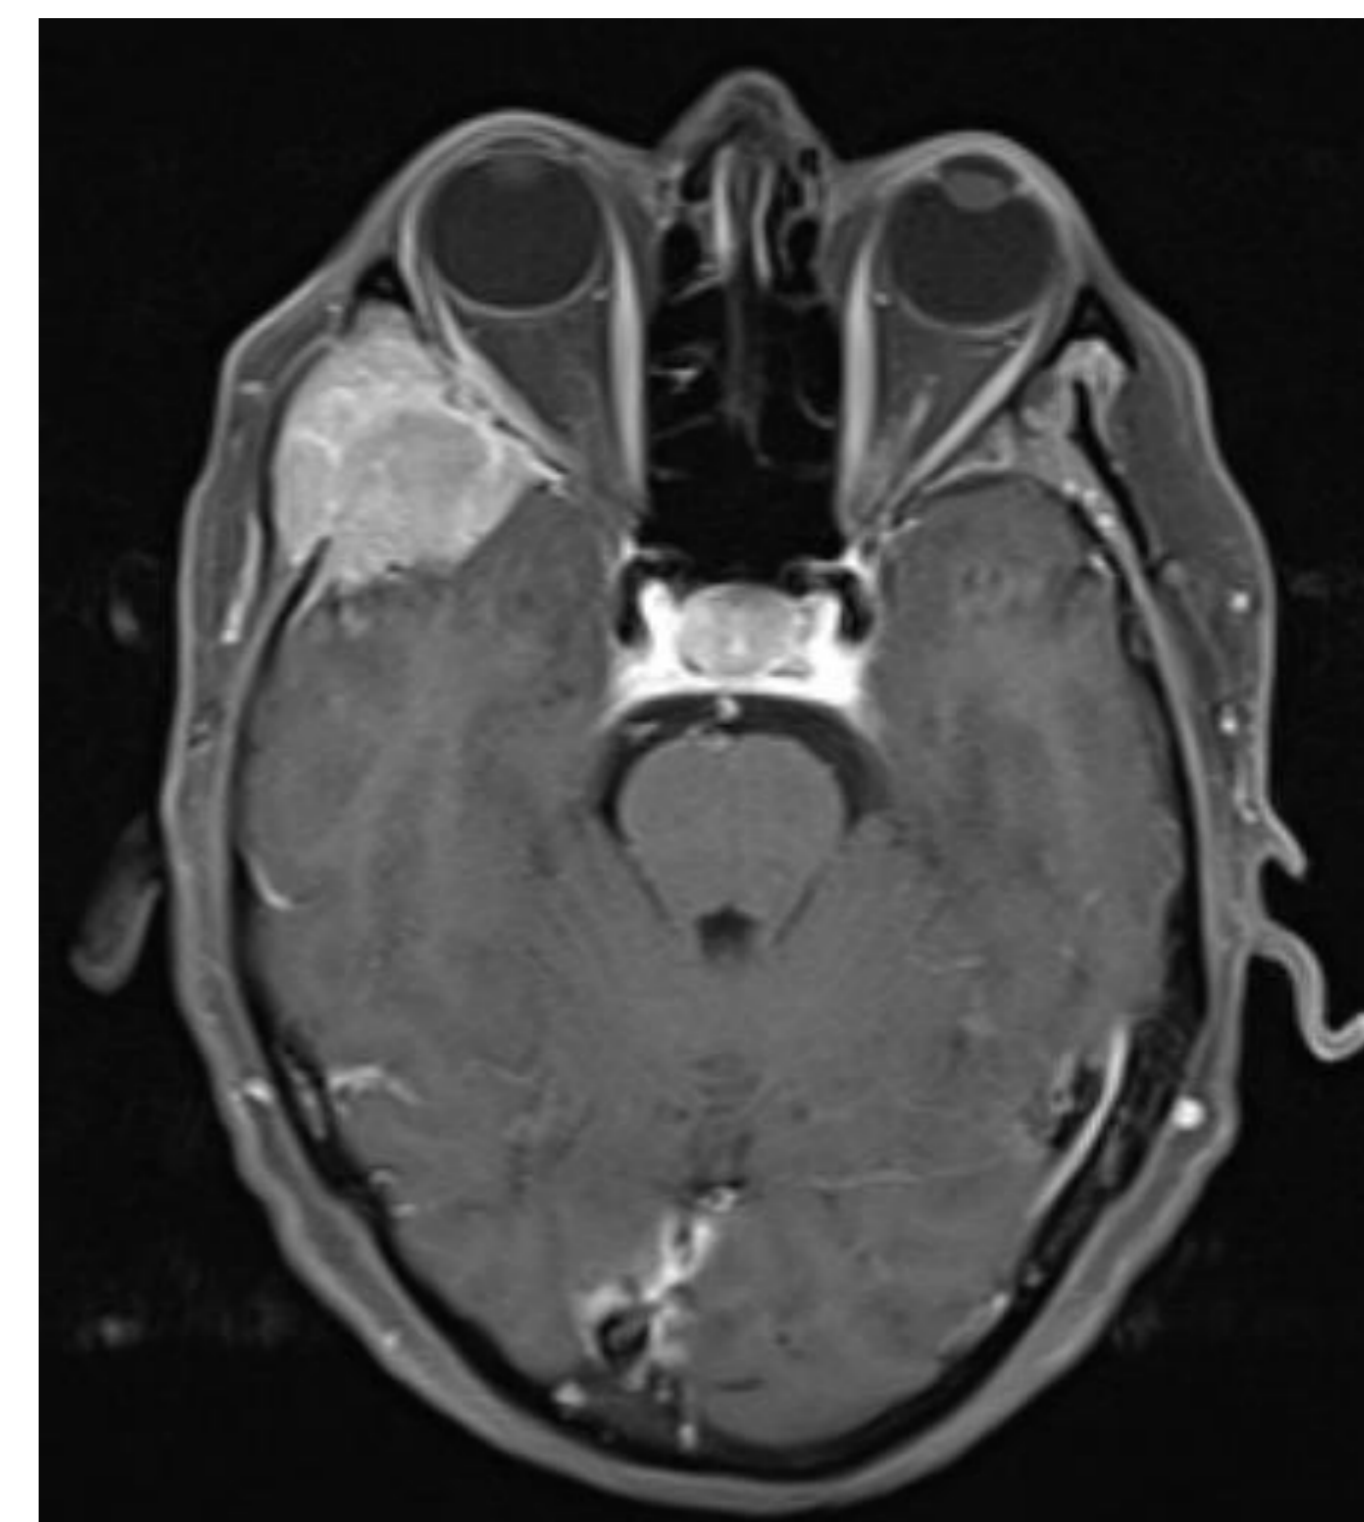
Axial T1 cranioencephalic MRI. Sphenoidal right greater wing extra-axial lesion.
